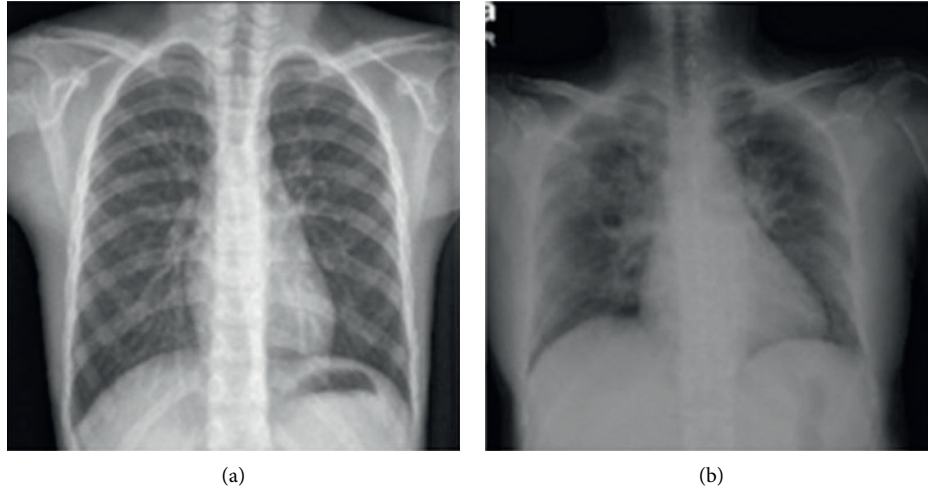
(a) Radiographic images of a healthy person's chest. (b) Chest radiographs of patients with COVID-19 [143].
